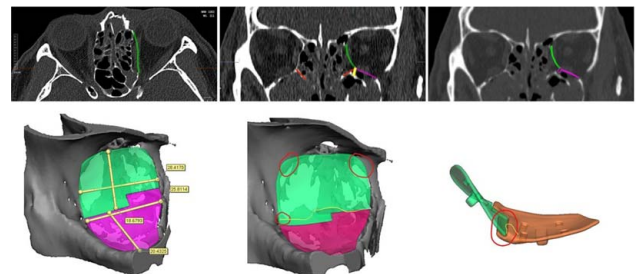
Communication for implant design. During the implant design, surgeons provide necessary implant requirements based on CT information they capture. Subsequently, implant manufacturers implement the implant shape through 3D rendering. Surgeons then provide detailed conditions, and the manufacturer communicates by reflecting these conditions in the design.
